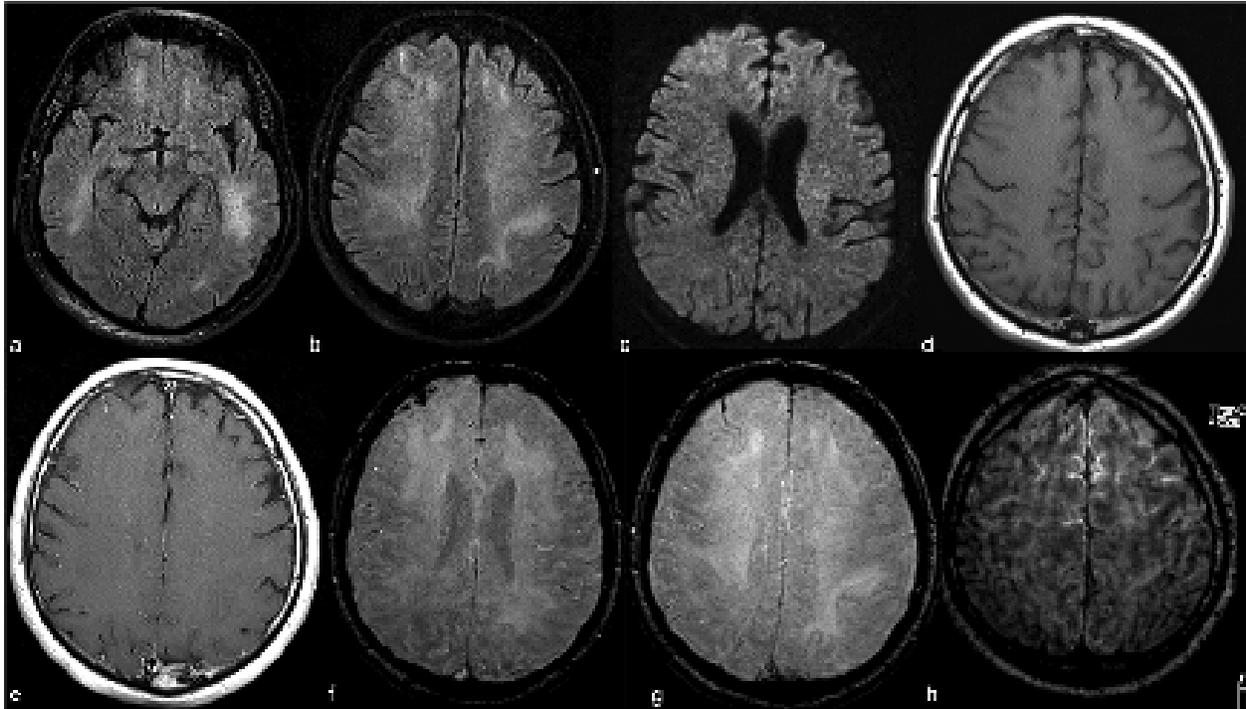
Contrast-enhanced cranial 1.5T MRI examination of a 59-year old intubated male patient with altered mental status despite tapering of sedoanalgesia. Axial FLAIR images at level of midbrain (a) and centrum semiovale (b) demonstrate prominent symmetric white matter hyperintensity and right frontal cortical hyperintensity. There is also prominent linear hyperintensity within frontal sulci. Axial b2000 DWI (c) shows frontal increased signal with corresponding low ADC (images not provided). Axial T1WI (d) shows right frontal sulcal effacement. Post-contrast T1WI (e) shows mild pial-subarachnoid enhancement. Axial SWI at the level of corona radiata (f) and centrum semiovale (g) demonstrates blooming artifact in the frontal sulci. Post-contrast FLAIR (h) depicts the bilateral leptomeningeal enhancement. ADC apparent diffusion coefficient; FLAIR fluid-attenuated inversion recovery; SWI susceptibility weighted image.
